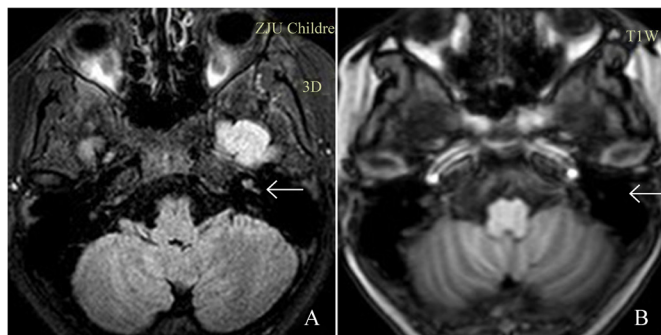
MRI features of the inner ear before treatment in an 8-year-old girl with cochlear hemorrhage in the left ear. (A) Three-dimensional fluid-attenuated inversion recovery (3D-FLAIR) axial image. (B) T1-weighted image (T1WI) axial image. The arrow indicates left cochlear hyperintensity (hyperintensity was not detected in T1WI).
